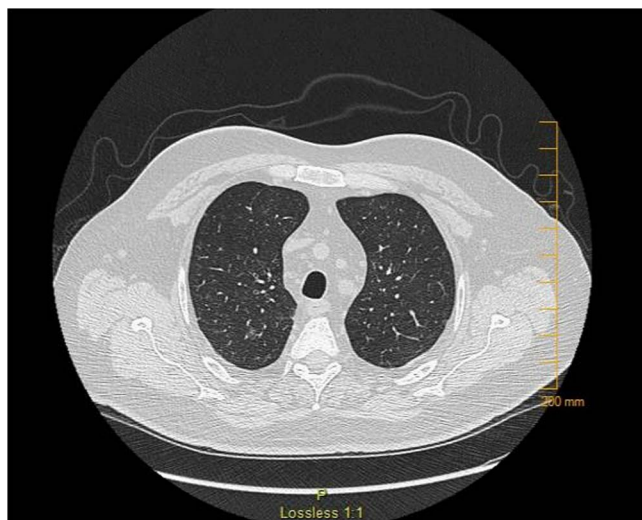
CT scan showing pulmonary nodules before treatment.
